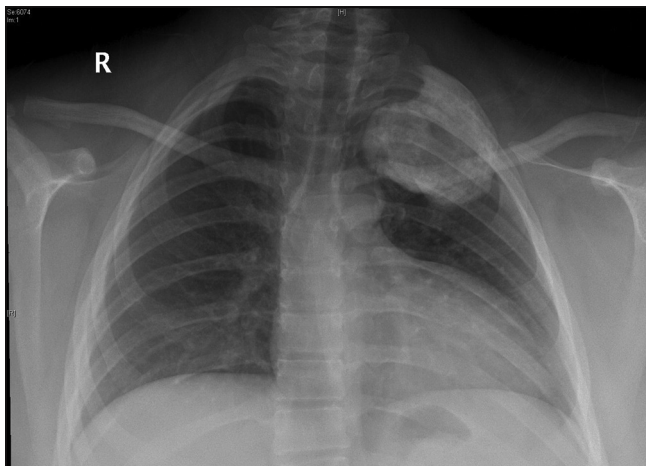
Chest X-ray showing a left 1<sup>st</sup> rib mass (8 × 6 × 4) cm in size
